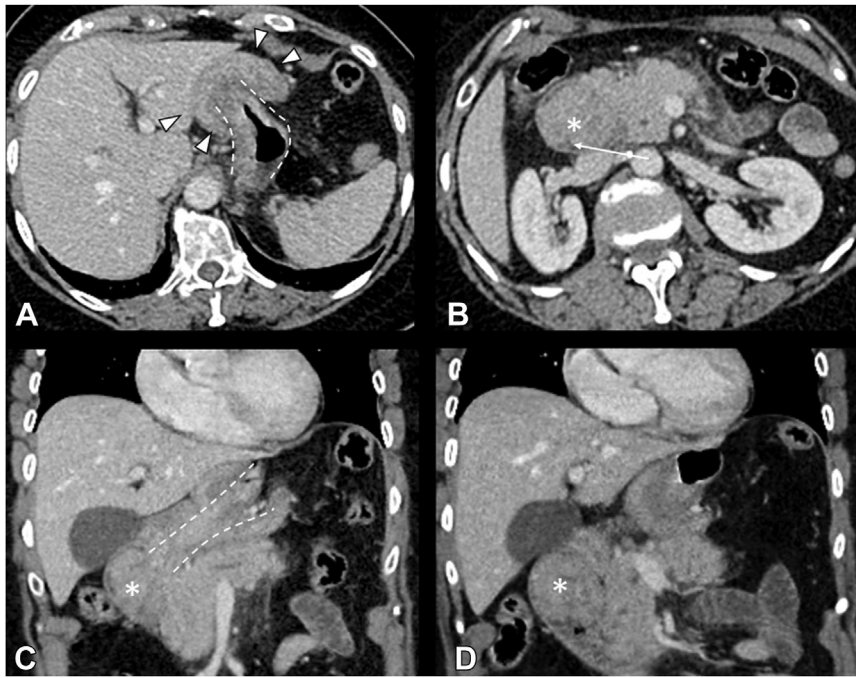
Contrast-enhanced CT scan of the abdomen and pelvis. Axial images: A, Gastrogastric intussusception with the intussusceptum (*dashed line*) telescoping into the intussusciptens (*arrowheads*). B, Lobulated mass (*asterisk*) serving as the lead point for the intussusception. Small-volume fluid (*arrow*) delineates the mass from the wall of the duodenum. Coronal images: C, Redemonstration of long-segment intussusception (*dashed line*) with lobulated mass (*asterisk*) serving as the lead point and extending into the proximal duodenum. D, Lobulated mass (*asterisk*) occupying and expanding the duodenal lumen.
